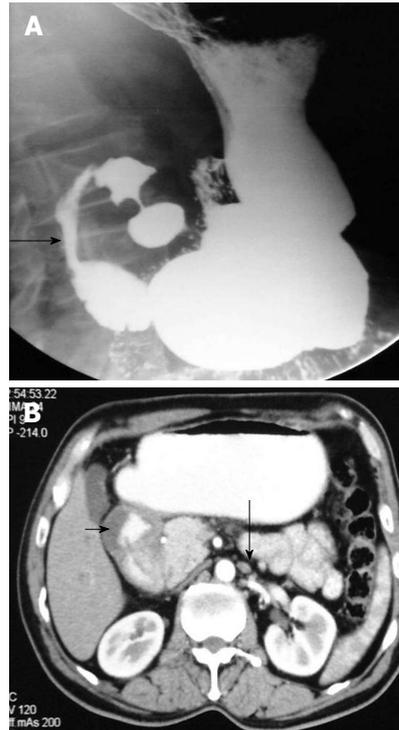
A long segment narrowing of the second part (arrow) of the duodenum is noted (A), axial computed tomography image (B) shows circumferential mural thickening of the duodenum (short arrow) with few para-aortic lymph nodes (long arrow). Endoscopic biopsy revealed a diagnosis of non-Hodgkin lymphoma.
